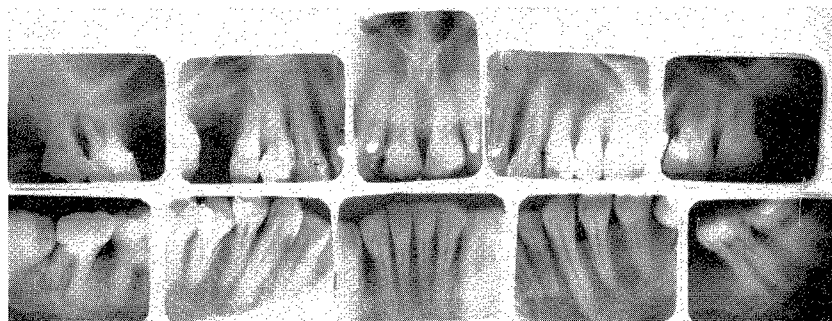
Roentgenograms taken in 1929 when the patient was in his early thirties. (Figs. 82 to 95 are of the same case.)
